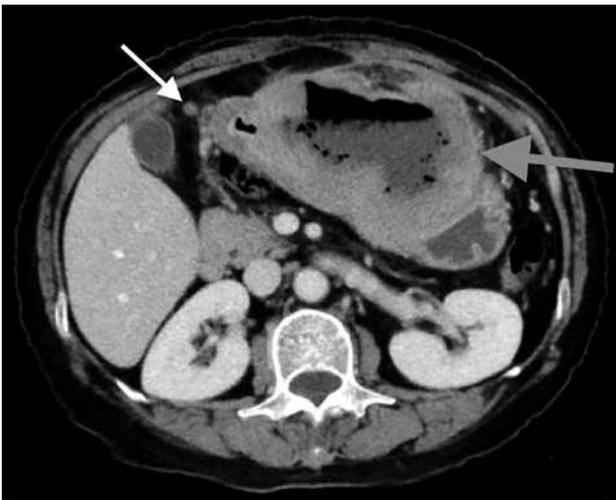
Gastric lymphoma in a 59-year-old woman. Contrast-enhanced computed tomography showing marked diffuse mural thickening of the stomach (grey arrow). Prominent lymph node adjacent to the gastric pylorus (white arrow) is suspicious of disease involvement.
